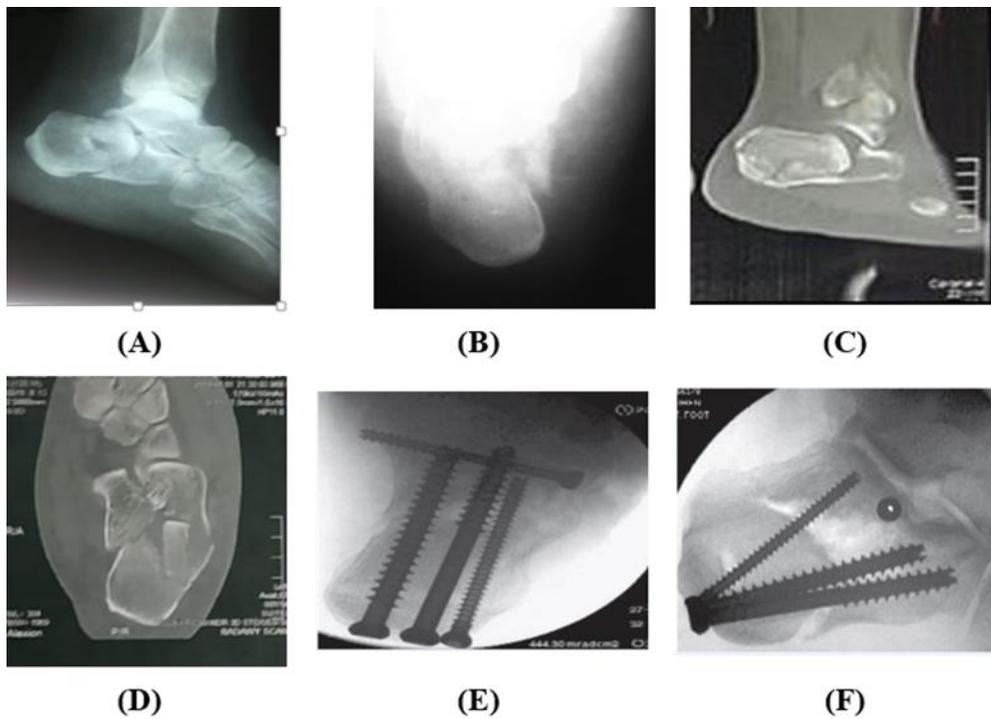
Case II: (A, B) pre-operative X-ray, (C, D) pre-operative CT (E, F) immediate post-operative X-ray, (Cannulated screws have been used).
